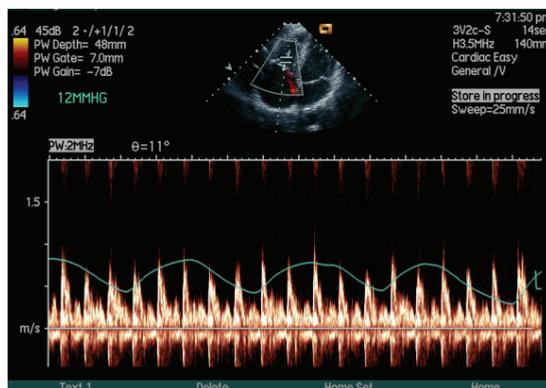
Doppler spectra across the tricuspid valve with the intrathoracic pressure decrease of 12mmHg in the same subject as in figure 1. RVI is 21.3%
